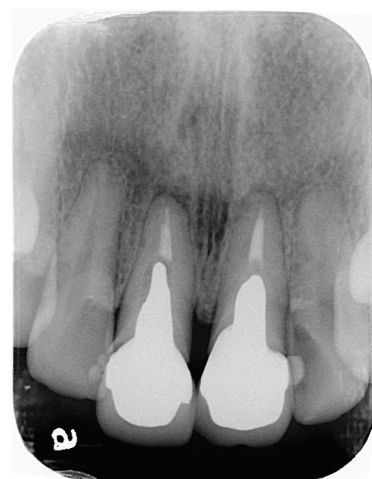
Initial periapical x-ray revealed over-sized posts
